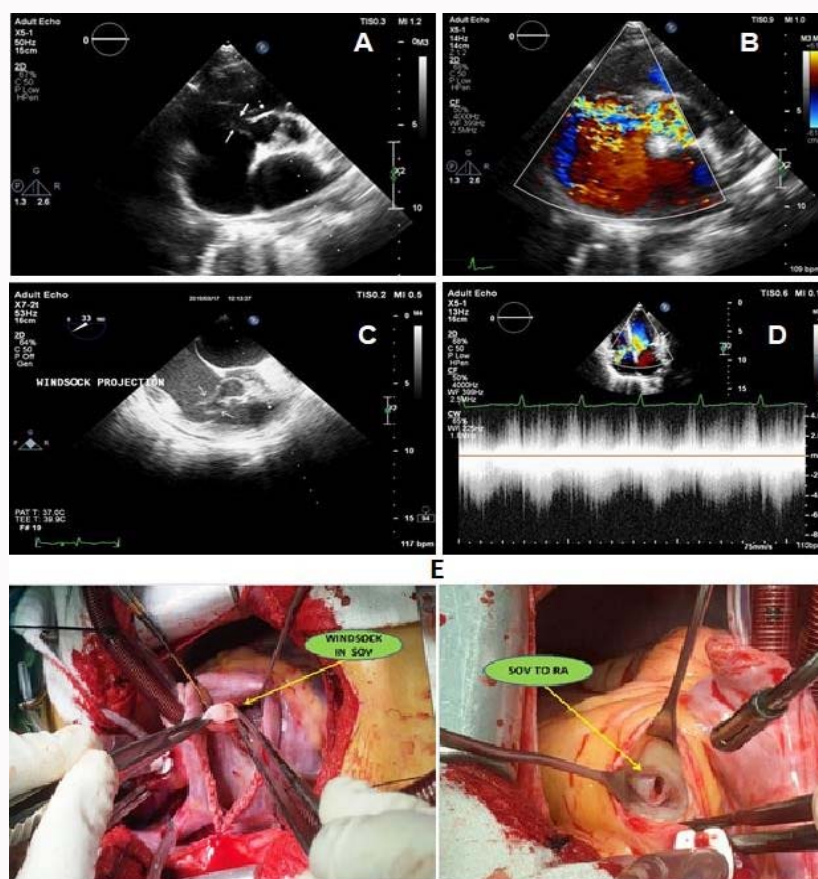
Windsock shape the aneurysmal medial sinus. Turbulent continues flow jet between the Right Atrium (RA) and medial aneurysmal sinus circulating in the RA. A: Short-axis view of transthoracic echocardiography showing the windsock; B: The color of A; C: Mid-esophageal transesophageal echocardiography (short-axis view of the aorta-windsock); D: Continuous flow of ruptured aneurysm in transthoracic echocardiography (four-chamber view). E: Large aneurysm of the right coronary sinus with windsock formation.
